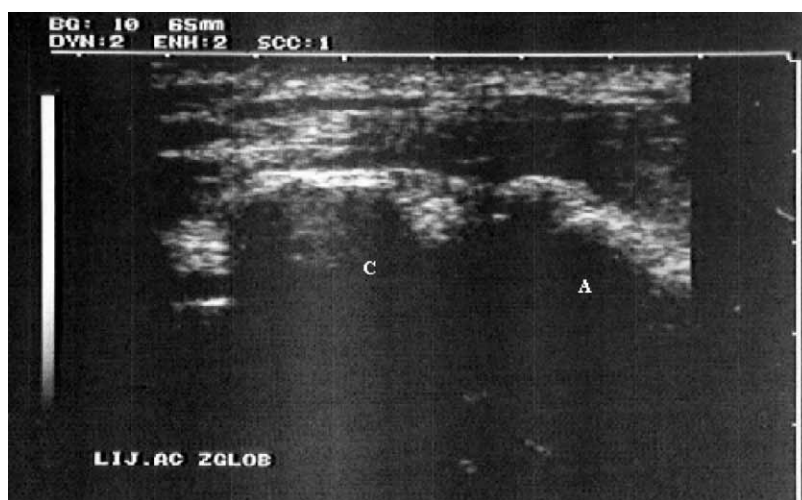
Ultrasound of the left acromioclavicular (A–C) joint. Note irregular A–C joint facets, especially on the acromial side.
